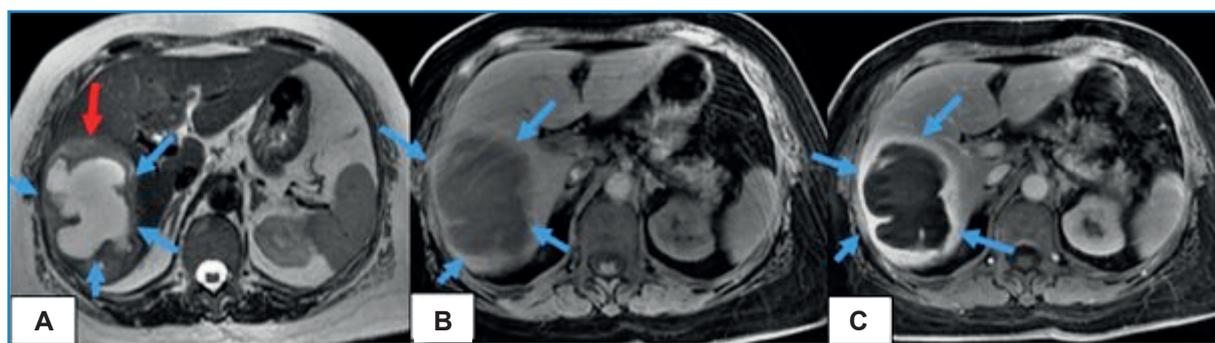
Magnetic resonance imaging scan showing a A) hyperintense lesion on T2-weighted imaging (blue arrows) with perilesional edema (red arrow), a B) hypointense lesion on T1-weighted imaging (blue arrows), with an C) enhancing peripheral rim-like thick capsule (blue arrows).
